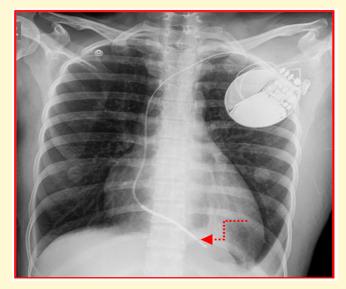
Chest Radiograph showing single-lead Permanent pacemaker with tip of lead in right ventricle (insitu).
